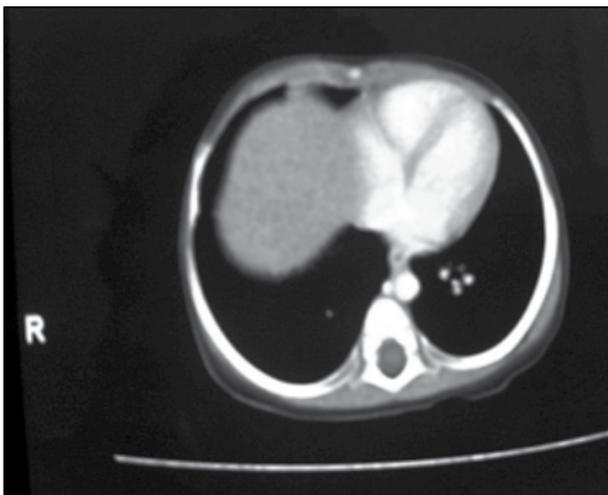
Computed tomography scan showing right lobe hepatoblastoma compressing the inferior vena cava
